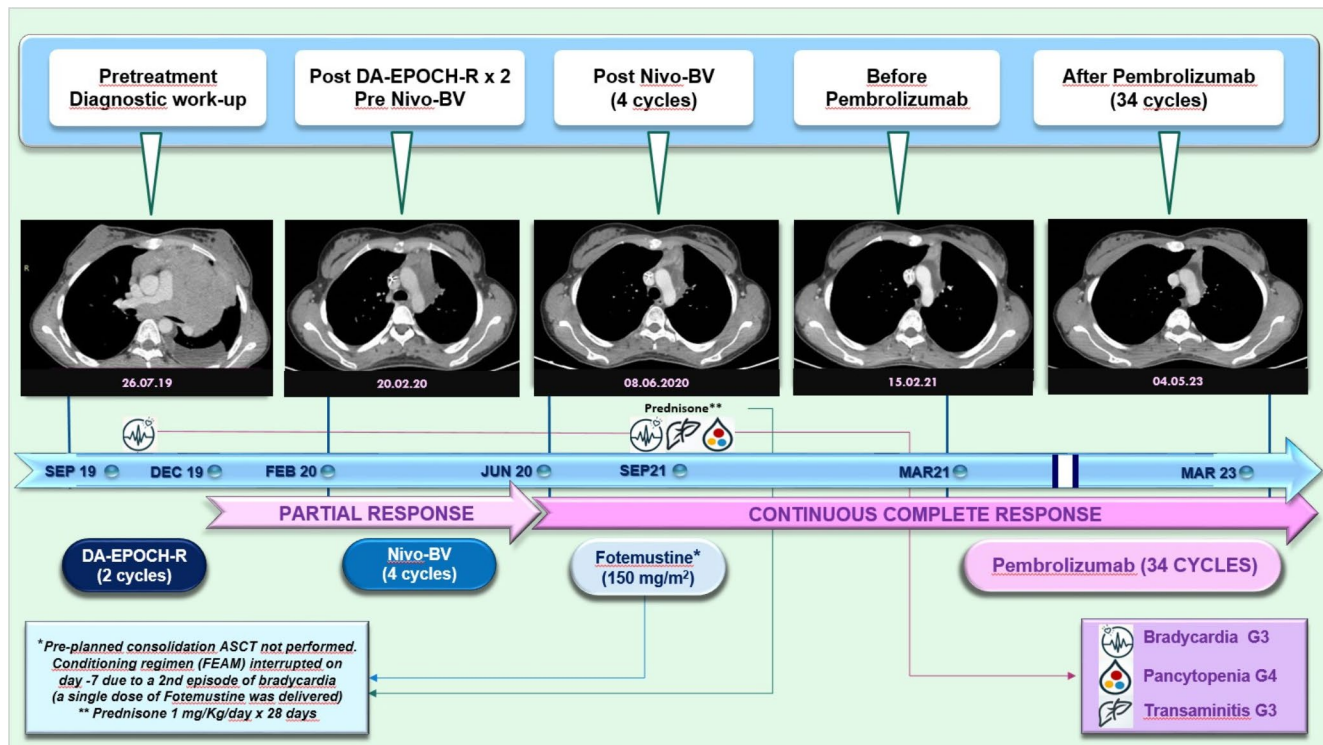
Visual timeline and case summary including major clinical findings, treatments, chest computed tomography scans and toxicity episodes
